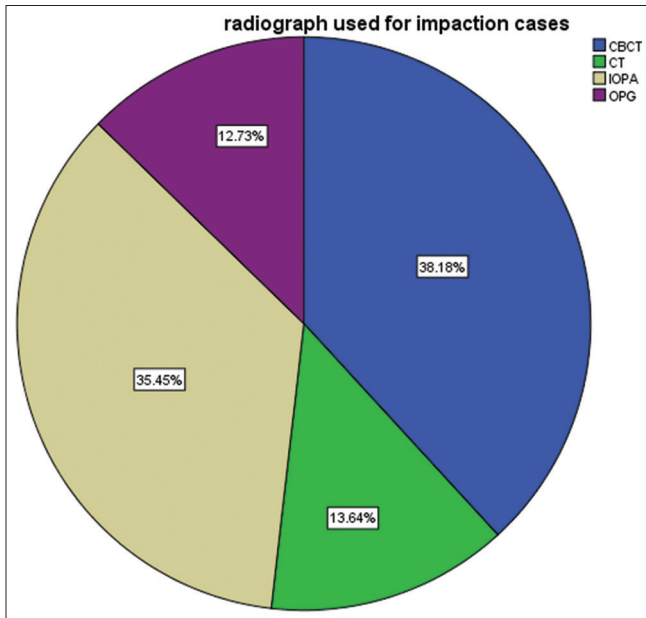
The responses for radiographs used for impaction cases
